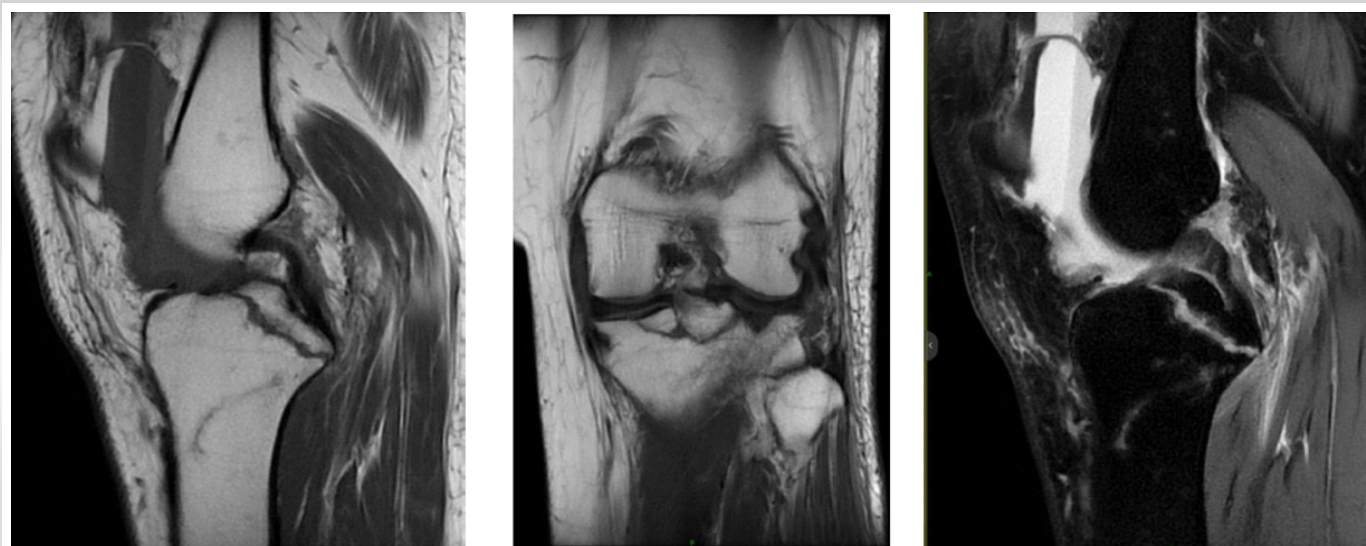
Magnetic resonance imaging of the left knee, suggestive of a complete anterior cruciate ligament tear, posterior cruciate ligament tibial avulsion fracture, lateral meniscus posterior root tear and Posterior horn medial meniscus tear.
